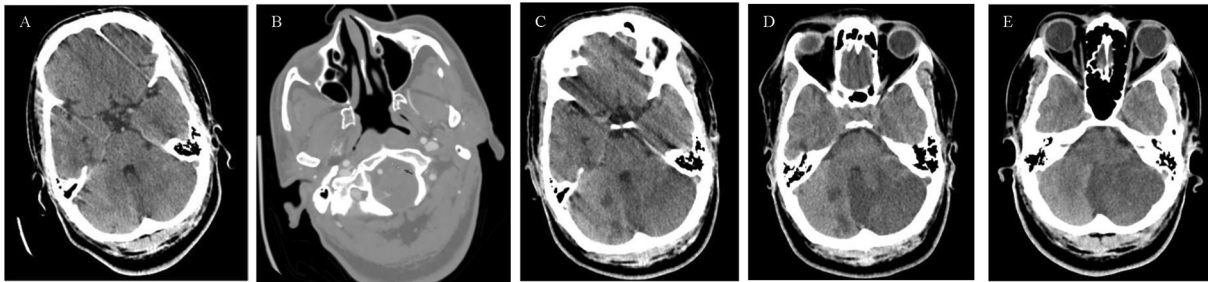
Noncontrast Head CT Time Course. A. Hospital Day 5. Noncontrast head CT at time of stroke alert, note no hypodensity, no hydrocephalus and no mass effect on fourth ventricle. B. CT Angiogram head at time of stroke alert, note vertebral artery occlusion (arrows). C. Hospital Day 6. CT head non-contrast shows left cerebellar infarct with effacement of the CP angle cistern and left-to-right midline shift without hydrocephalus, fourth ventricle remains patent. D. Hospital Day 7. CT head non-contrast shows evolving left cerebellar stroke with increasing mass effect on the fourth ventricle without hydrocephalus. E. Hospital Day 9. CT head non-contrast shows left cerebellar infarct with significant mass effect on the fourth ventricle and paramesencephalic cistern. No hydrocephalus.
